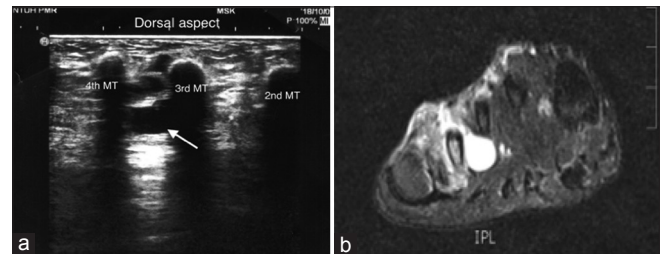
(a) Follow-up ultrasound images showing the transverse view of the right dorsal foot. (b) Magnetic resonance imaging T2-weighted image of the right dorsal foot, coronal view. (MT: Metatarsal bone, Arrow: The lesion)
